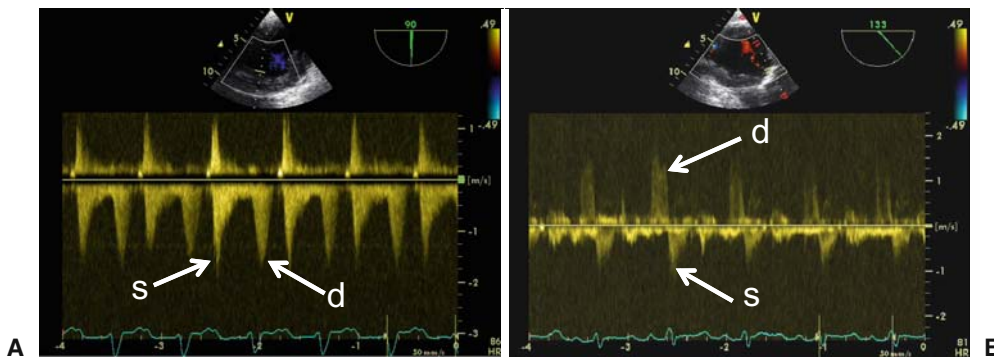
Intraoperative transthoracic echocardiography (TEE) after bypass in case 2 (transgastric left-ventricular long-axis view). A Continuous-wave Doppler across apical outflow showing conduit flow during systole ($\leftarrow s$) and mitral flow during diastole ($\leftarrow d$). B Continuous-wave Doppler across native aortic valve showing native flow during systole ($\leftarrow s$)
